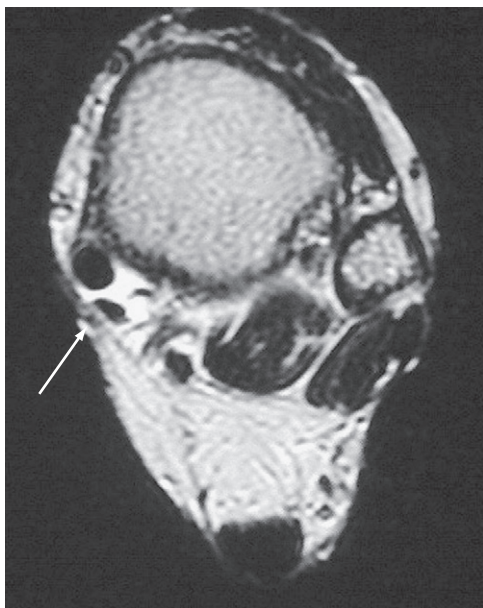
Axial magnetic resonance image of ankle demonstrating posterior tibial tendon degeneration and synovitis (arrow).
